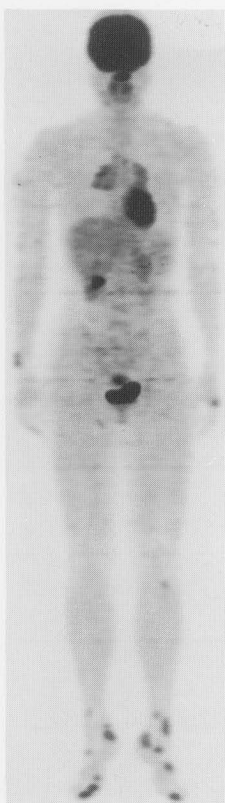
Whole-body FDG PET (maximum intensity projection image) demonstrated multiple sites of FDG uptake in the hilar lymph node, right ulna, left hand, bilateral feet, pubic bone, and the subcutaneous tissue of the extremities.
